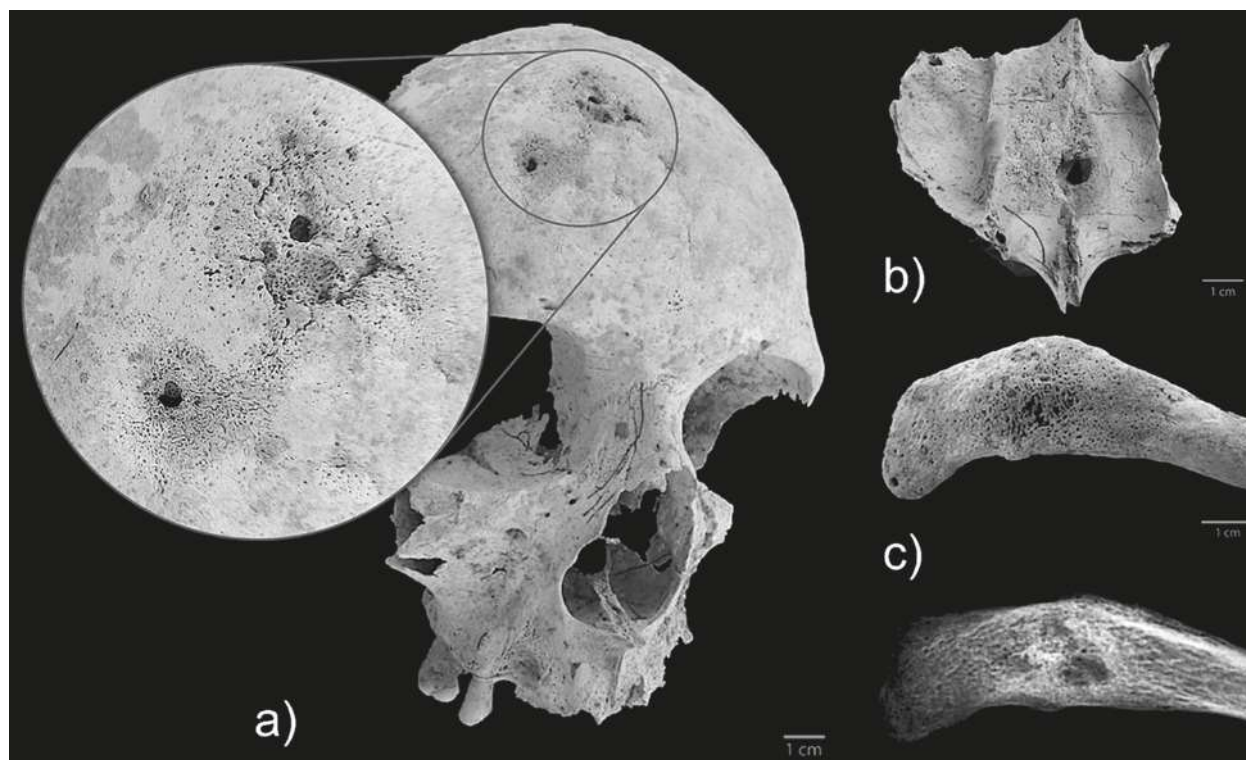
SMOL 18.188; a) Frontal bone with destructive circular lesions and woven bone deposition; b) Palate's perforation and woven bone deposition; c) Perforating lesion surrounded by woven bone on the clavicle (photo and radiography).
